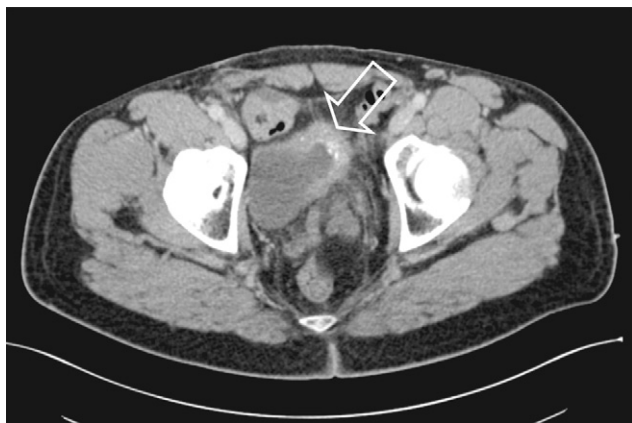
Urinary bilharziasis. Axial view contrast-enhanced CT scan: retraction, thickening and calcifications of the anterior wall of the bladder (arrow).
